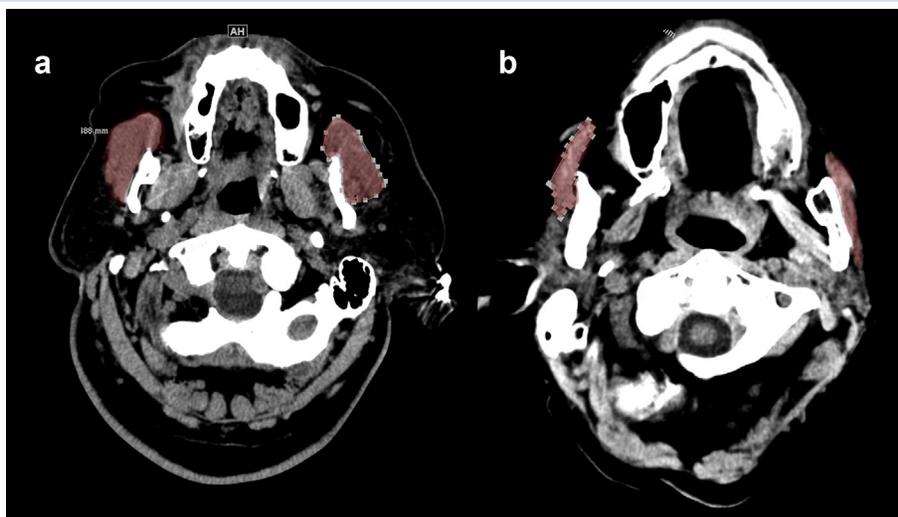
CT assessment of masseter muscle sarcopenia. The masseter muscle is the main muscle of mastication and can be identified (coloured in red) in cranial Computed tomography (CT), using horizontal images 1 cm caudad to the zygomatic bones. (a) Normal masseter cross-sectional area and (b) masseter muscle sarcopenia.
